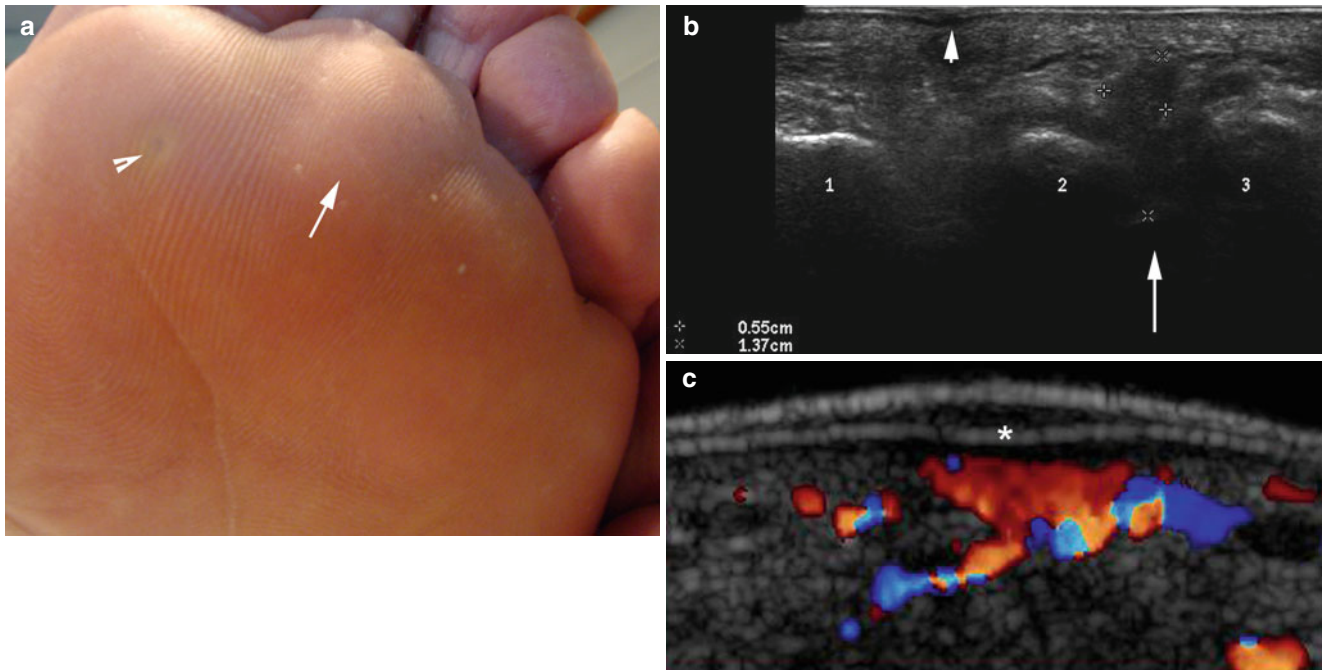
(a–c) Morton's neuroma and plantar wart. (a) Clinical image shows a hyperkeratotic lesion (*arrowhead*) in the sole of the left foot. Nevertheless, the patient presented with exquisite pain in the second intermetatarsal space (*arrow*, between the 2nd and 3rd metatarsal bones). (b) Grey scale ultrasound image (transverse view, metatarsal level) shows a 0.55×1.37 cm hypoechoic mass (*large*
